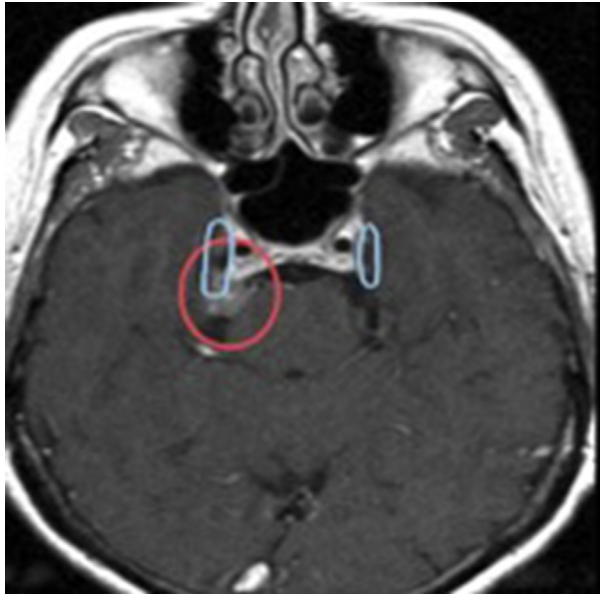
Axial magnetic resonance image obtained with contrast material: the red circle outlines the lesion and the blue circles outline the Meckel cave.
